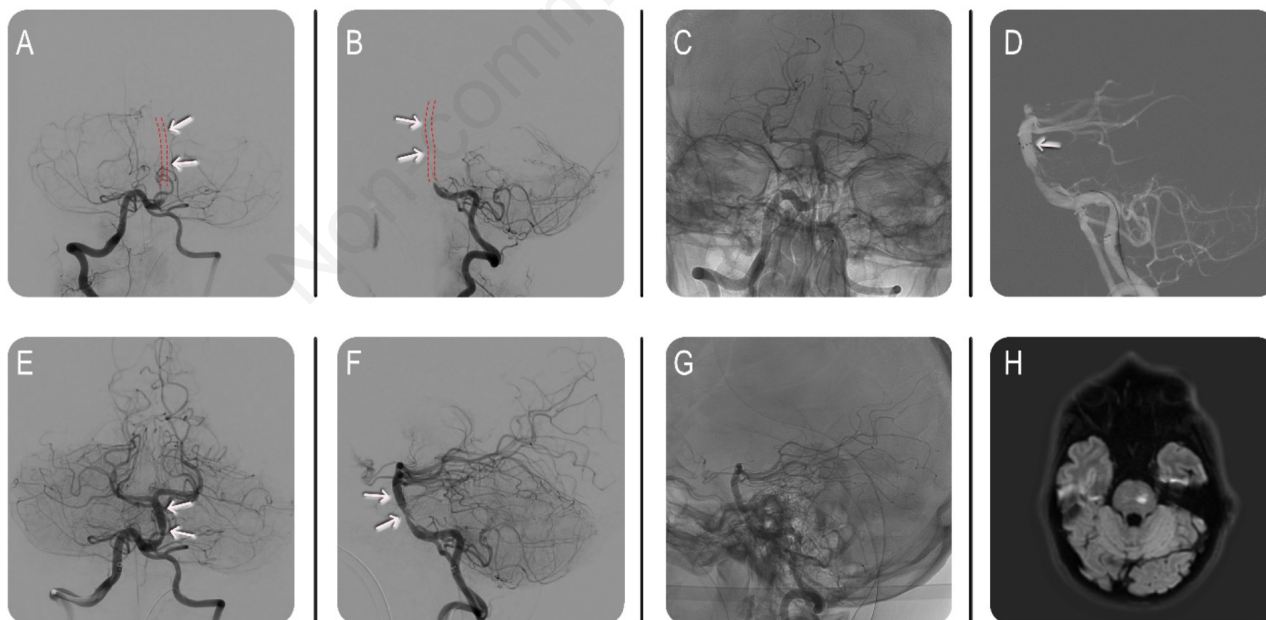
Digital subtraction angiography (DSA) demonstrating occlusion of the basilar artery (white arrows) before thrombectomy (red dotted lines describe the expected position of the basilar artery: A, frontal view; B, lateral view). After mechanical thrombectomy using a stent retriever, complete recanalization (white arrows) of the basilar artery (E, frontal view; F lateral view). In C and G the anatomical position of the recanalized basilar artery is shown superimposed on the skull image. The metal landmarks of the stent are visible, indicated with the white arrows in Figure D. MRI Diffusion Weighted Imaging (DWI) showed a small oval area of diffusion restriction on follow-up imaging at the left pontine tegmentum consistent with ischemic lesion (H).
